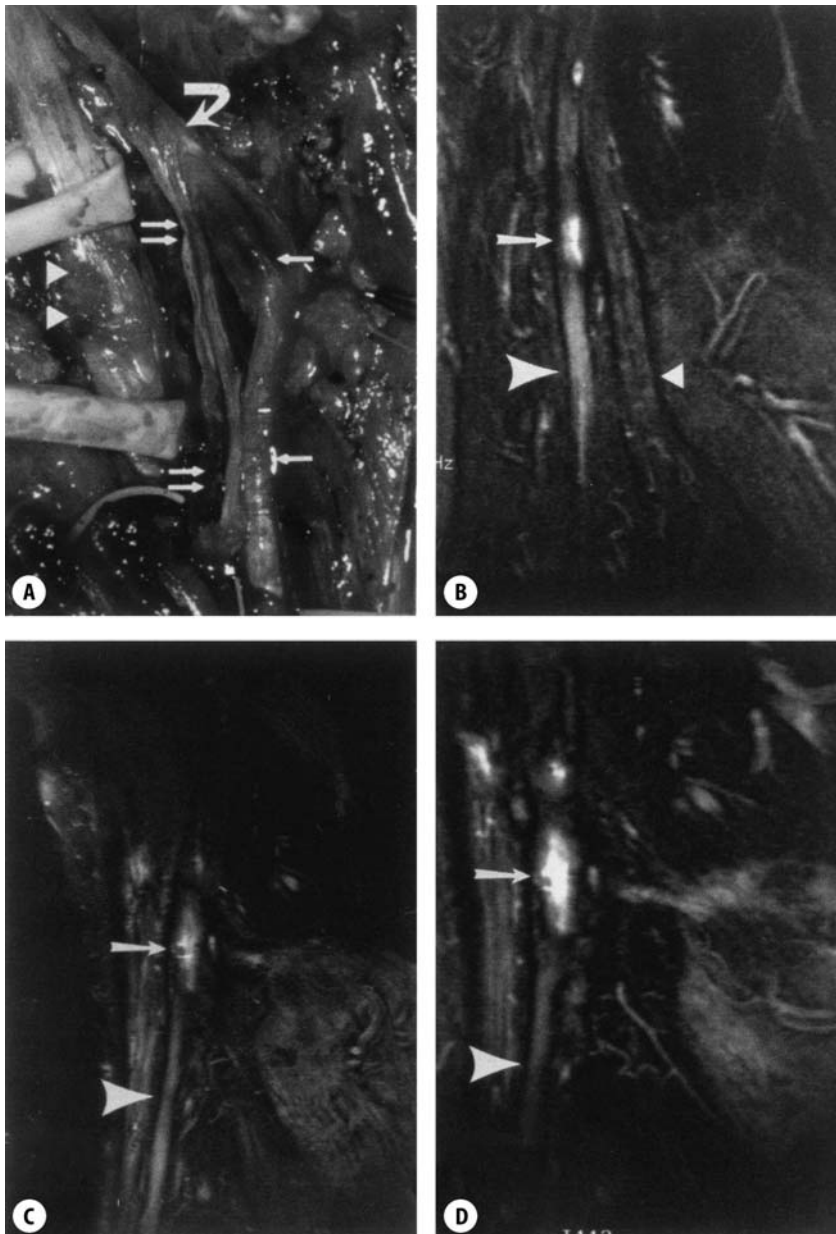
A 29-year-old man suffered a traumatic laceration to his right peroneal nerve, just above the popliteal fossa, resulting in a complete foot drop that had been suture repaired. He failed to recover peroneal nerve function and, 6 months later, a coronal T2-weighted MR image b visualized high signal in the nerve at (white arrow) and distal to (white arrowhead) the suture repair site. At the second operation a, performed 8 months after the first, no nerve conduction response could be recorded across the scarred suture-repaired segment of the peroneal nerve. This scarred segment was excised and the resultant gap bridged by two sural nerve grafts (a, double white arrows), leaving several sensory fascicles intact (a, single arrows). Eight months later, the patient began to show clinical and electromyographic evidence of muscle reinnervation and a coronal T2 MR image c showed partial return to normal of the bright signal in the distal peroneal nerve (white arrowhead). By 16 months, strength in peroneal-supplied muscles was near normal, the EMG confirmed additional muscle reinnervation and the coronal T2 MR image showed further normalization of signal in the distal peroneal nerve (white arrowhead), while signal remained high at the graft repair site (c and d, white arrow). (from [13]).
